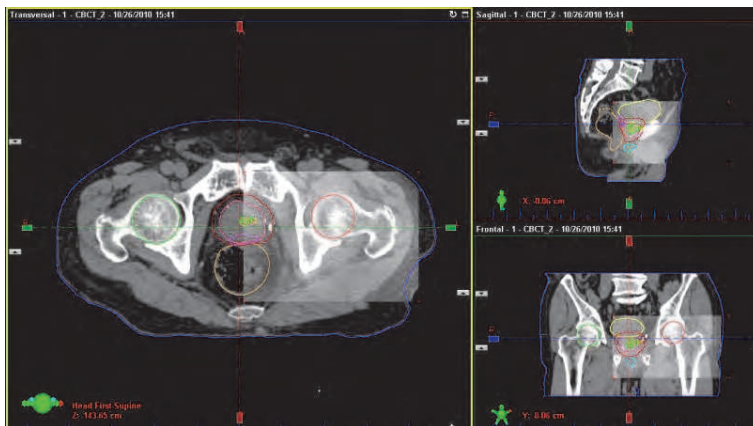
CBCT guided patient registration using AM software. The CBCT image (inter-ROI) was acquired to compare with the planning CT (Outer-ROI).
